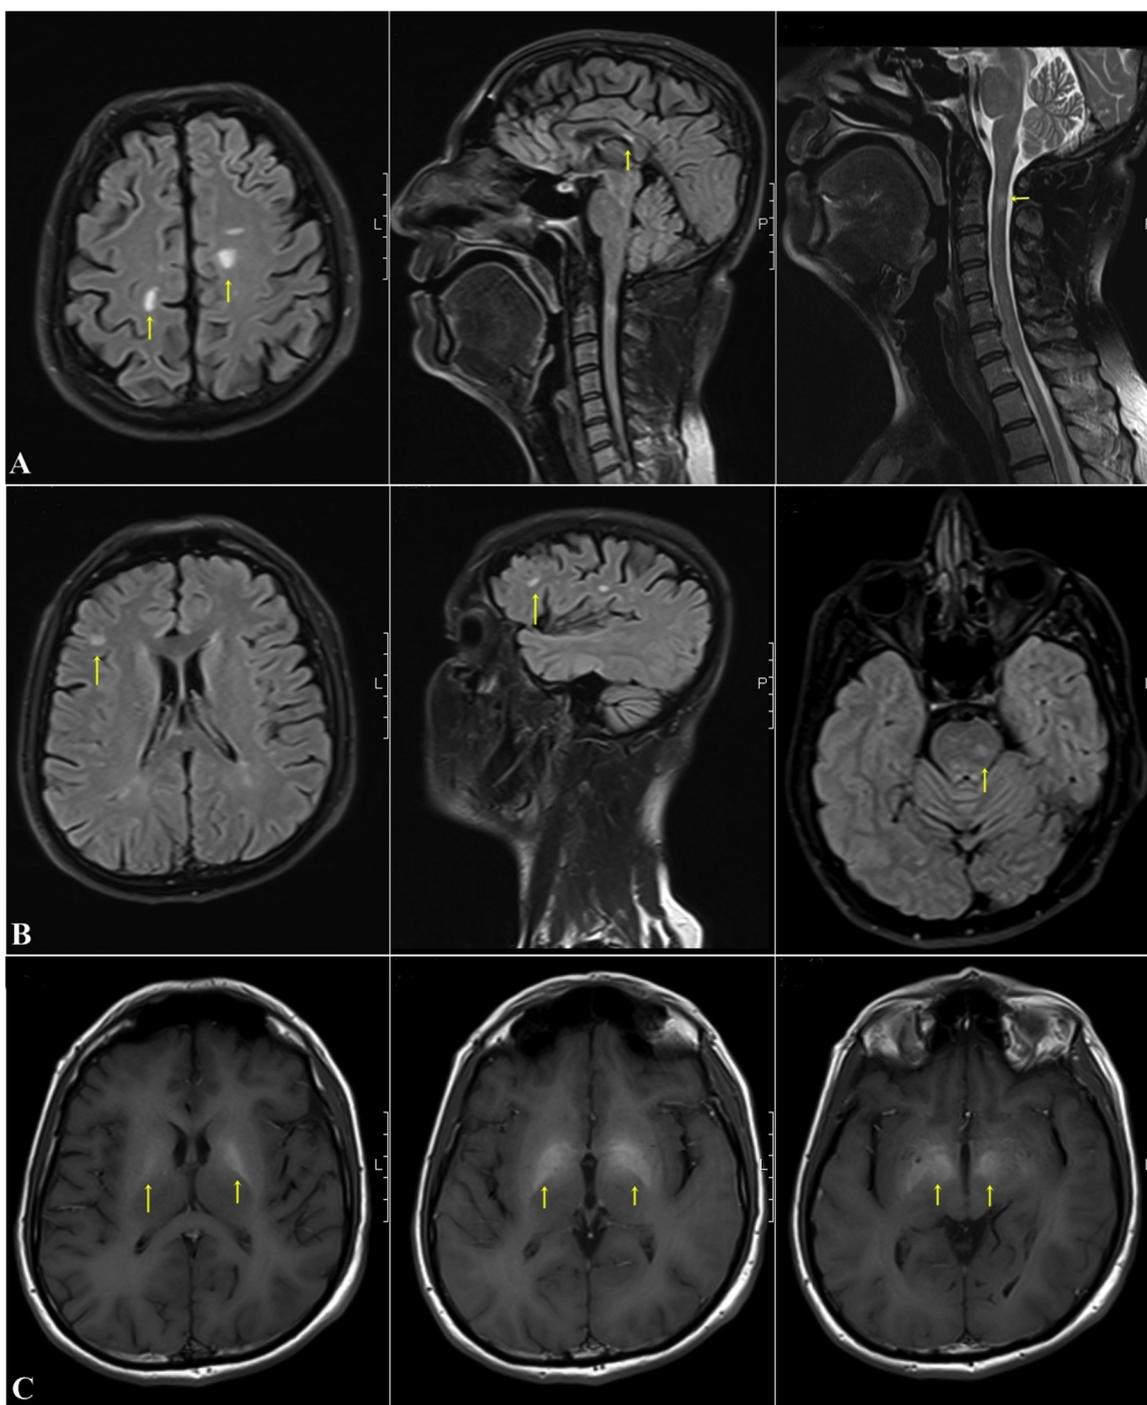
Initial brain MRI revealed multiple white matter high signal lesions on T2 and FLAIR images in corpus callosum, periventricular regions and cervical spinal cord without gadolinium enhancement suggestive for demyelinating disorders (A). MRI revealed a new area of abnormal signal intensity in the subcortical white matter of the right frontal lobe and in the left side of pons (B). Repeated MRI revealed basal ganglia hyperintensity on T1 weighted images (C).
